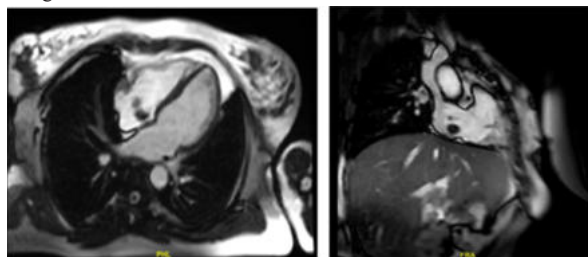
MRI images showing poorly enhancing, mixed-signal intensity masses suggestive of right atrial myxomas
